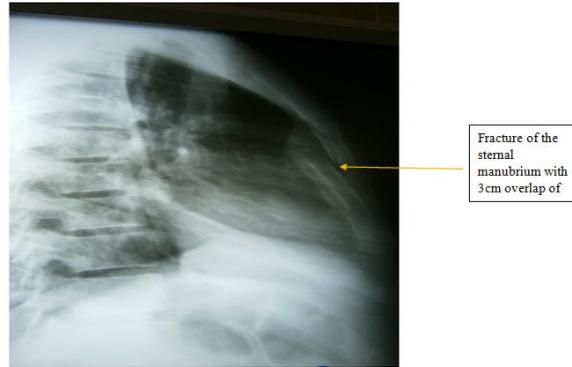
Standard radiograph of profile showing a stepped fracture of the sternal manubrium with 3cm overlap of the distal segment
